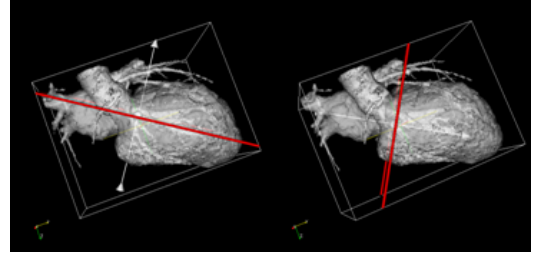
Selection of the echographic plane in the CT data (apical 4-chambers long axis plane (left) and short axis plane (right)).
